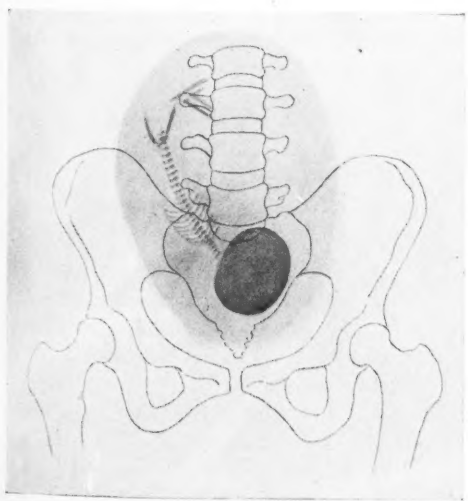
Twenty-five weeks' pregnancy. Fetus evidently considerably less developed than many at 20 to 24 weeks. (Full-term fetus delivered 15 weeks after date of roentgenogram.) Prone view.
